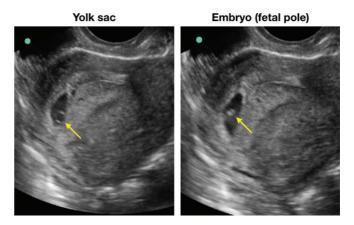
Yolk sac and fetal pole on transvaginal ultrasound.
